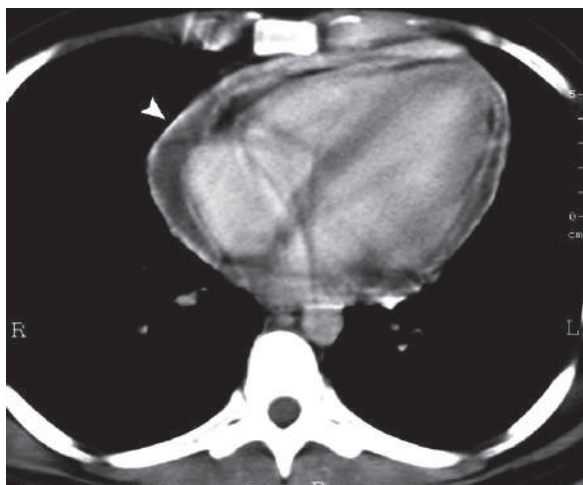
Axial postcontrast cardiac CT with contrast shows pericardial enhancement (*arrowhead*) with moderate pericardial effusion in a patient with acute pericarditis
